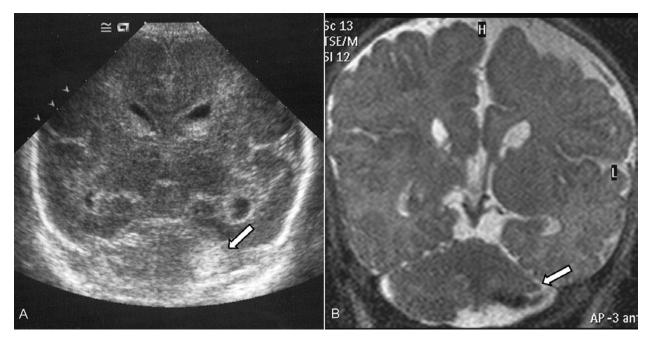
Cranial US appearance of intraparenchimal cerebellar haemorrhage in the early neonatal period (Figure 2A) as globular echolucency and coronal T2-weighted image at term postmenstrual age showing cerebellar atrophy and hemosiderin deposits (Figure 2B).
